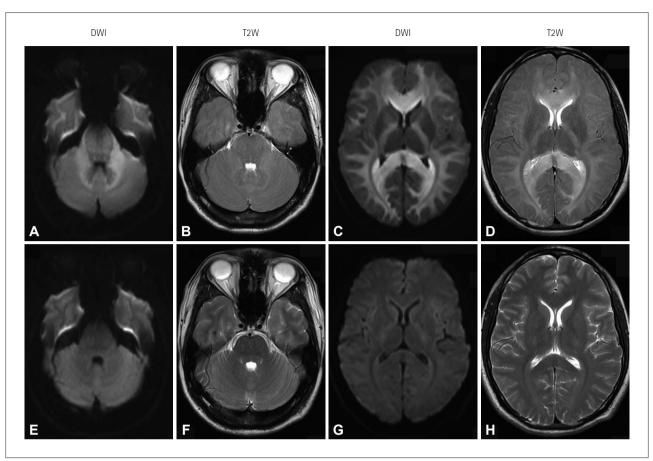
Neuroimage findings of this patient. A-D: Initial brain MRI showed symmetrical hyperintensities in the brain stem, cerebellum, corpus callosum, internal capsule, and subcortical spaces. E-H: Follow-up brain MRI performed 3 months later revealed complete resolution of these lesions. DWI: diffusion-weighted imaging, T2W: T2-weighted.
